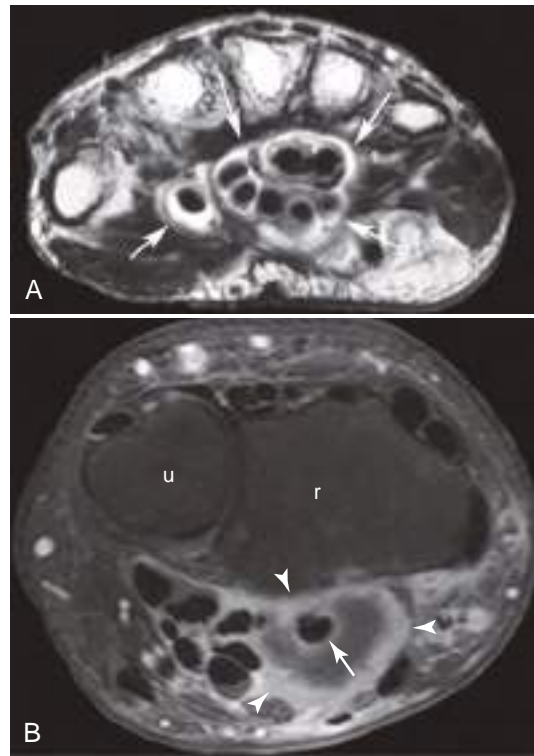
Tenosynovitis. (A) Carpal tunnel tenosynovitis due to overuse. Axial T2-weighted fast spin-echo MR image shows fluid distention of the carpal tunnel tendon sheaths (arrows). (B) Infectious tenosynovitis. Axial fat-suppressed contrast-enhanced T1-weighted MR image through the distal forearm at the distal radioulnar joint shows distended, enhancing tendon sheath (arrowheads) and low-signal-intensity fluid surrounding the flexor pollicis longus tendon (arrow). The nonenhancing fluid in the tendon sheath in this case was pus related to *Staphylococcus aureus* infection. r, Radius; u, ulna.
